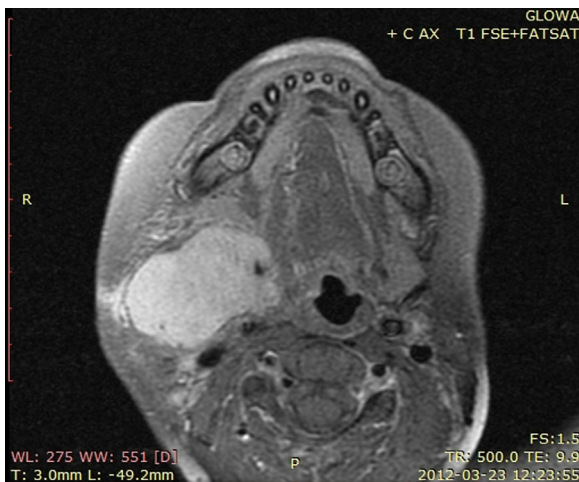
MRI of the neck before surgical treatment. Visible large right sided tumor enhanced after contrast infusion.
